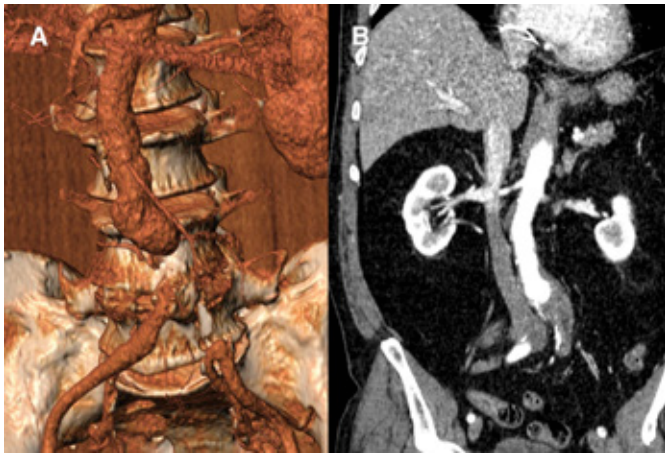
A) The 3D reconstruction of the preoperative CTA that was performed at the time of patient’s admission, revealing a complete occlusion of the lumen of the aortic bifurcation and the left common iliac artery. B) In coronal view, the thrombosed post-dissection infra-renal aortic aneurysm of 4,5cm and the occlusion of the lumen of the infrarenal aorta was detected by the pre-operative CTA.
